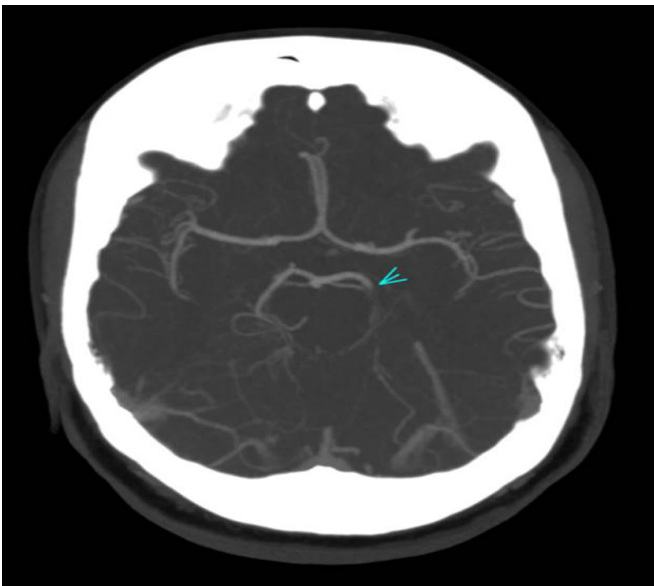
Transverse CT angiogram MIP showing abrupt termination of perfusion in the left posterior cerebral artery marked with an arrowhead.
